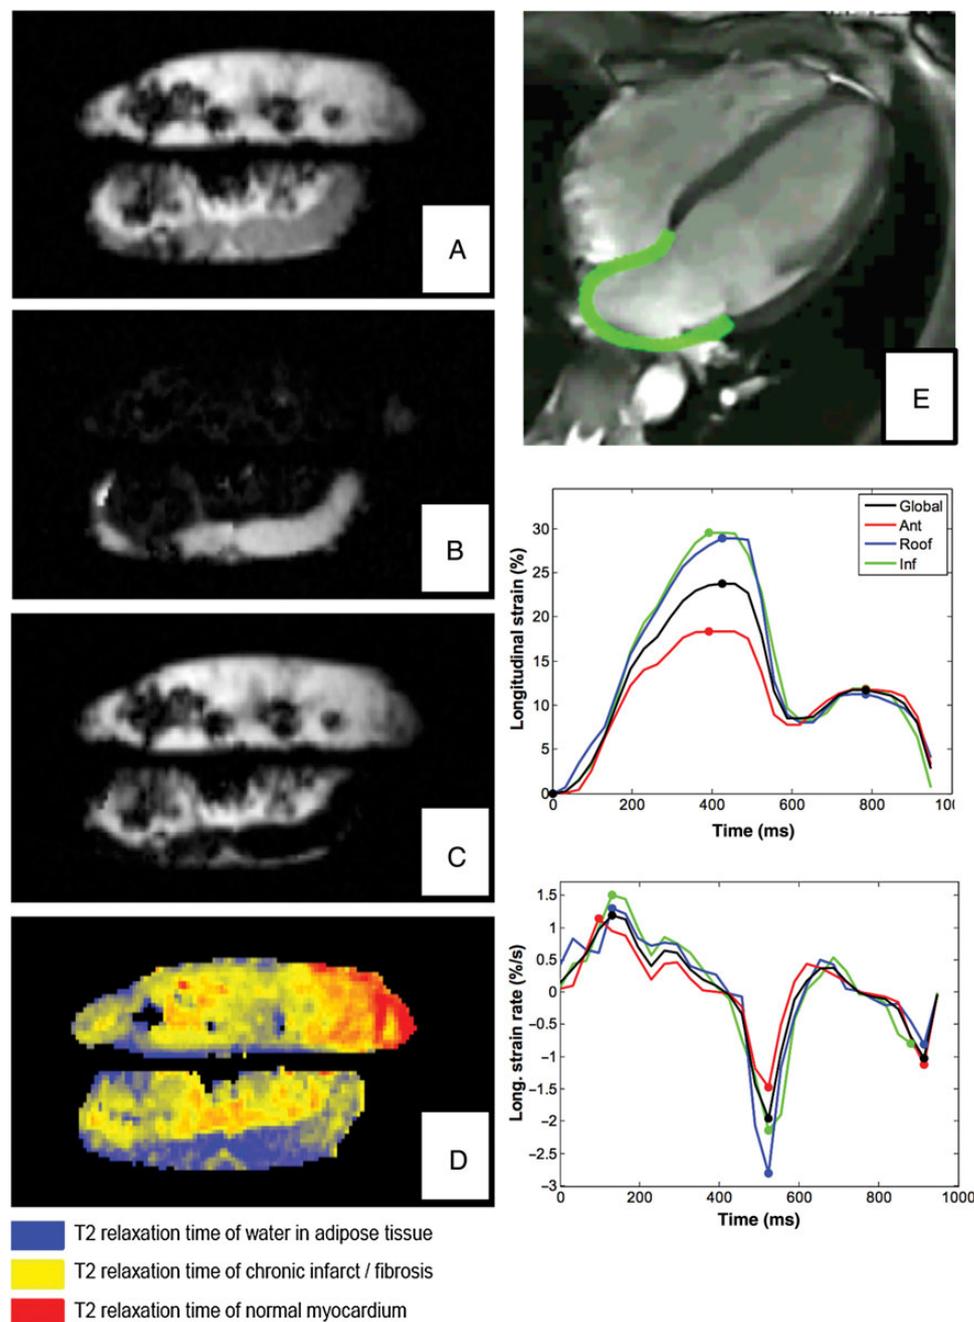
Ex vivo* high-resolution MRIs of two human LA tissues. (A) Image acquired with GRE sequence with the echo time TE at which water and fat signals are in phase. (B) Fat image obtained using the Dixon method. (C) Water image obtained using the method. (D) Map of T2 transverse relaxation time values reveals a fibrotic region in the fatty tissue. (E) LA strain measurement using MRI feature tracking and resulting longitudinal strain and strain rate curves.
